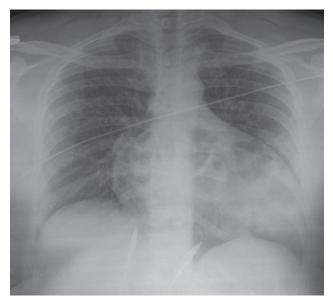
Chest radiograph demonstrating abnormal air shadowing over the enlarged pericardial sac.
